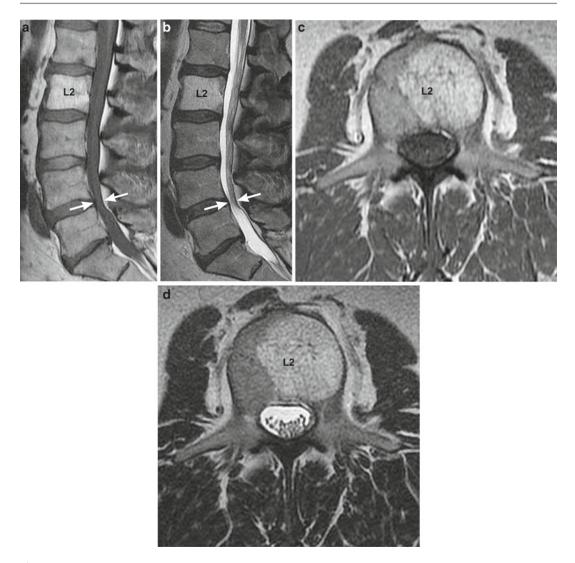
Lumbar spinal canal stenosis. Sagittal T1 (a)-weighted and T2 (b)-weighted MRI images in a patient with low back pain demonstrate hyperintense T1 and T2 signal in the L2 vertebral body. Axial images at the L2 level with T1 (c) and T2 (d) weighting are confirmatory.
